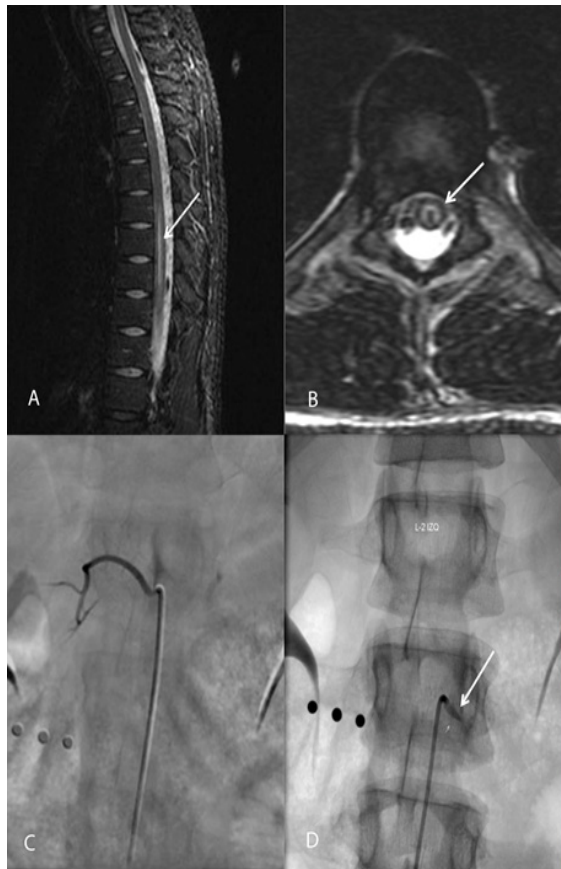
(A) and (B) Spinal magnetic resonance imaging. (A) Sagittal Short-T1 Inversion Recovery (STIR) (B) Axial T2 weighted image show linear hyperintensity within central thoracic spinal cord. Increased hyperintensity within central gray matter with sparing of spinal cord periphery is suggestive of acute ischemic lesion. (C) and (D) Angiographic study (C) Normal lumbar 1 right segmental artery (D) Lumbar 2 left segmental artery with proximal obliteration suggestive of steno-occlusive dissection.
